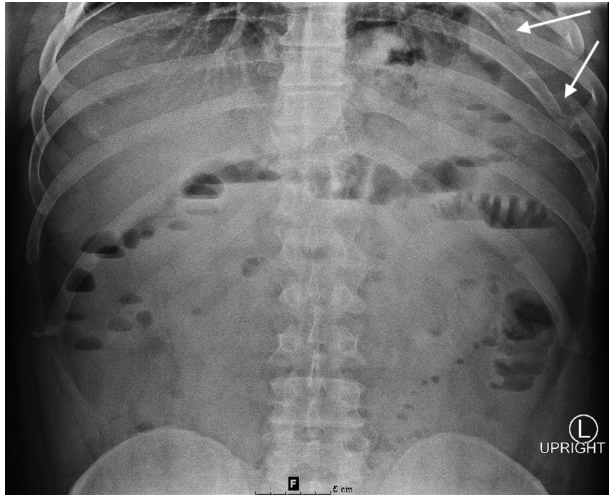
Radiograph of abdomen, upright anteroposterior projection, of a 38-year-old male, demonstrating chronic rib fractures (arrows) on the left with nonspecific bowel gas pattern.
